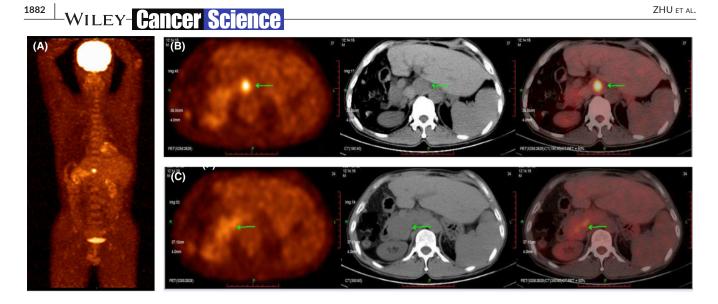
Positron emission tomography/computed tomography scan before chemotherapy. A, Positron emission tomography/computed tomography scan revealed abdominal multiple lymph node enlargements with increased glucose metabolism, with maximal standardized uptake value (SUVmax) as 6.53. B, C, Green arrows show two primary enlarged irregular nodes
